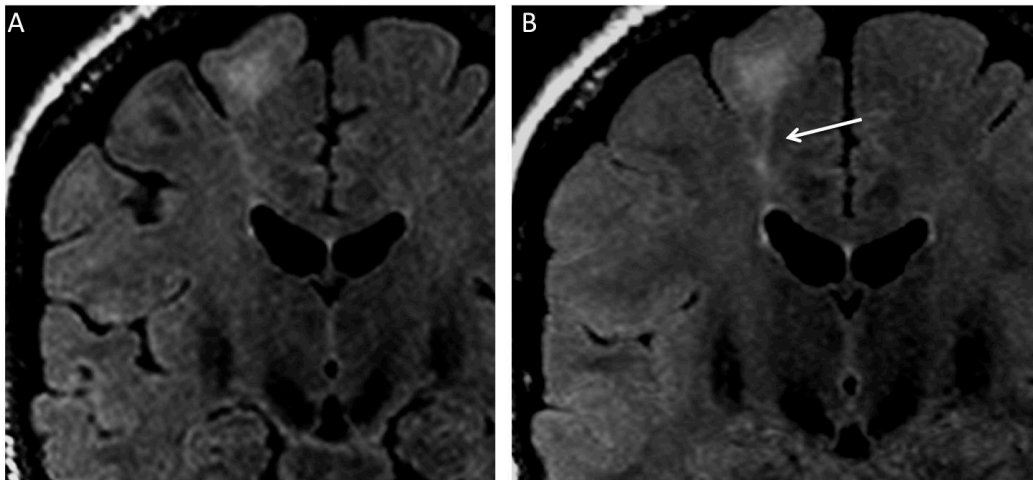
Intérêt de l'utilisation du MIP pour la détection du Transmantle Sign. Reformatage coronal d'une séquence 3D FLAIR sans (A) puis avec utilisation du MIP (B), chez un patient porteur d'une DCF2 frontale supérieure droite. Le « transmantle sign » (flèche) est mieux visible après application de cet algorithme.
